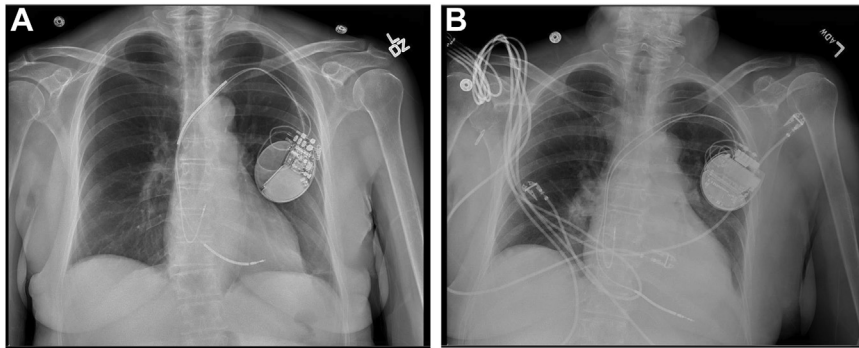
Image of chest radiograph. A: Before generator replacement. B: After generator replacement.
